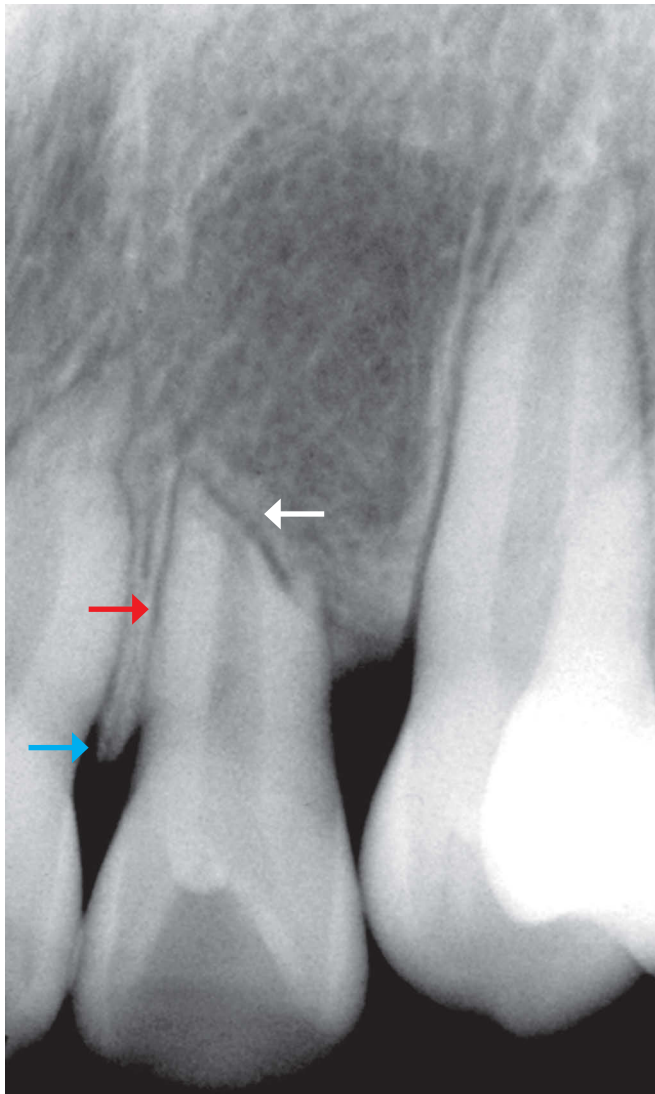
Plane and more advanced inflammatory apical root resorption, associated to occlusal trauma, with lamina dura thickening (white arrow), broadening of the periodontal space (red arrow) with periapical periodontal bone density increase in this area and V-shaped vertical bone loss (blue arrow). This phase with inflammatory apical resorption occurs after a long period of overloading.
